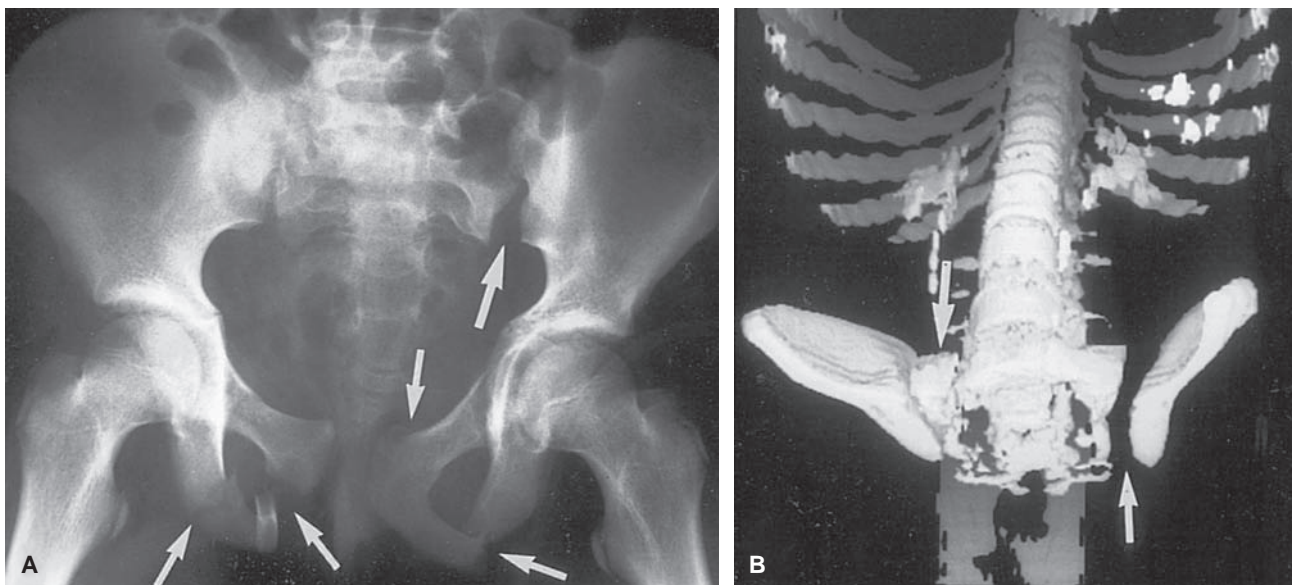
An unstable pelvic injury. A: On the plain film, multiple fractures of the pubic rami (*small arrows*) and widening of the right sacroiliac joint (*large arrow*) are apparent. B: On the three-dimensional reconstruction of the CT scan, the left sacroiliac fracture is even more obvious (*small arrow*), and a right-sided sacral fracture is also seen (*large arrow*).
